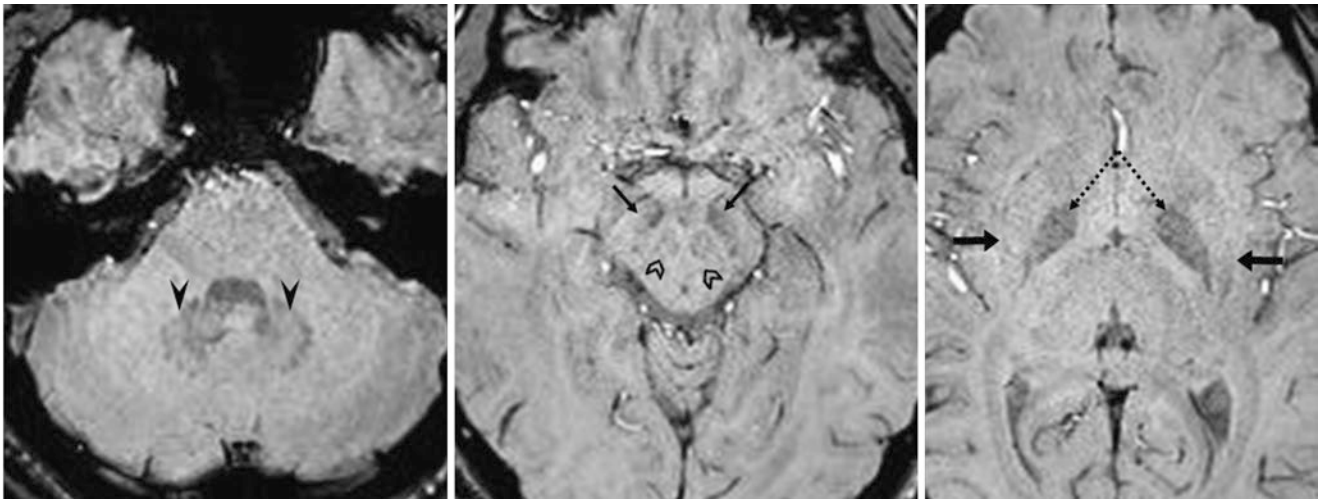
A 15 year old with a negative 3T MRI for headaches. Axial SWIs show early iron deposition within the dentate nuclei (*arrowheads*) as well as within the SN (*thin arrows*) and GP (*dotted arrows*).
